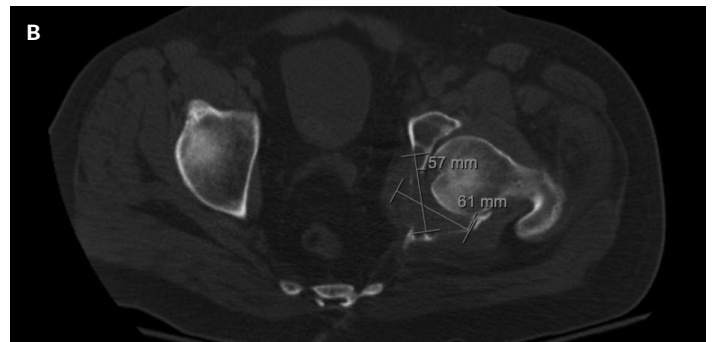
CT pelvis with pathologic fracture of left acetabulum through extensive lytic lesion.
